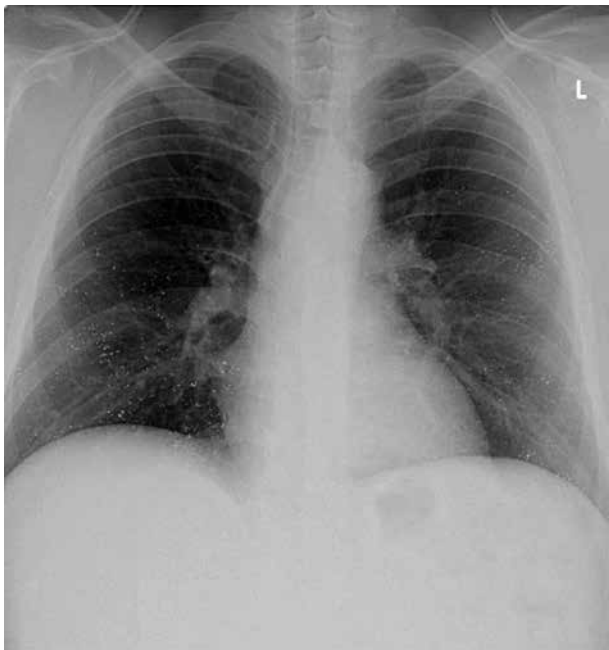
X-ray of chest showing diffuse radio-opaque mercurial deposits throughout the lung fields
